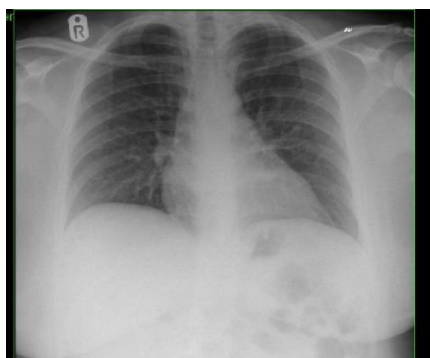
Her chest radiograph showed no evidence of free air beneath the diaphragm.
